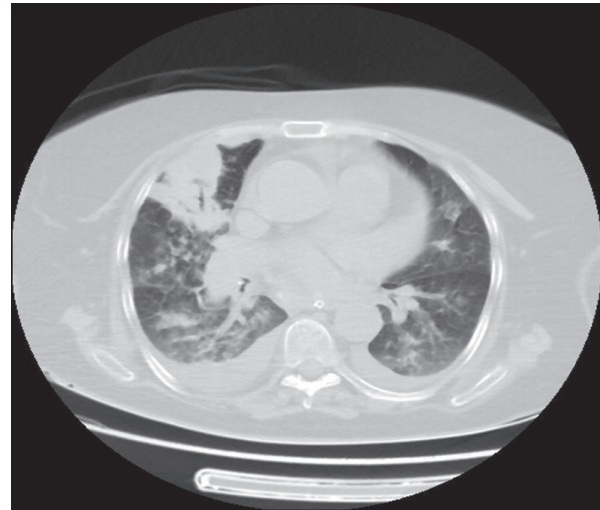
In the thorax CT, patchwork-like reticulonodular infiltration fields in bilateral lungs and sporadic frosted glass density fields was observed.
